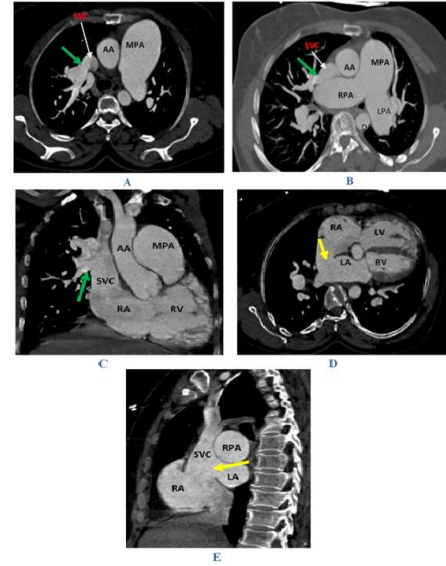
CT cardiac findings
